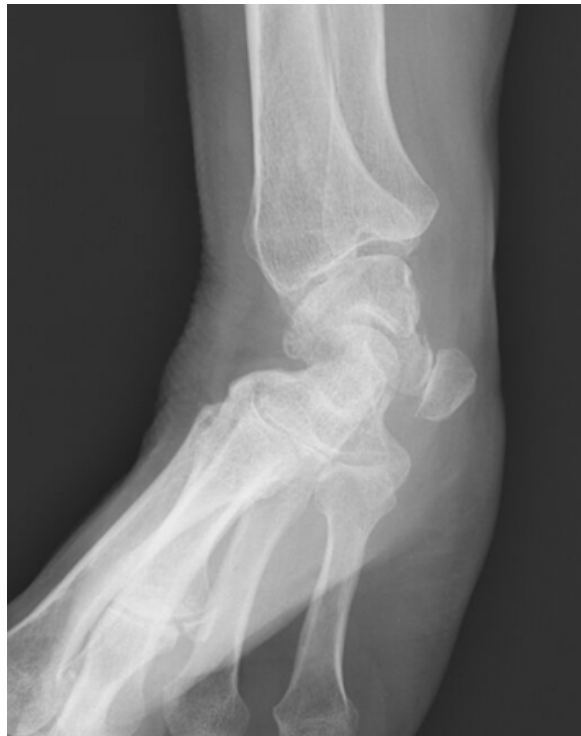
X-rays of primary pisotriquetral joint (PTJ) osteoarthritis (wrist in 30° supination)
